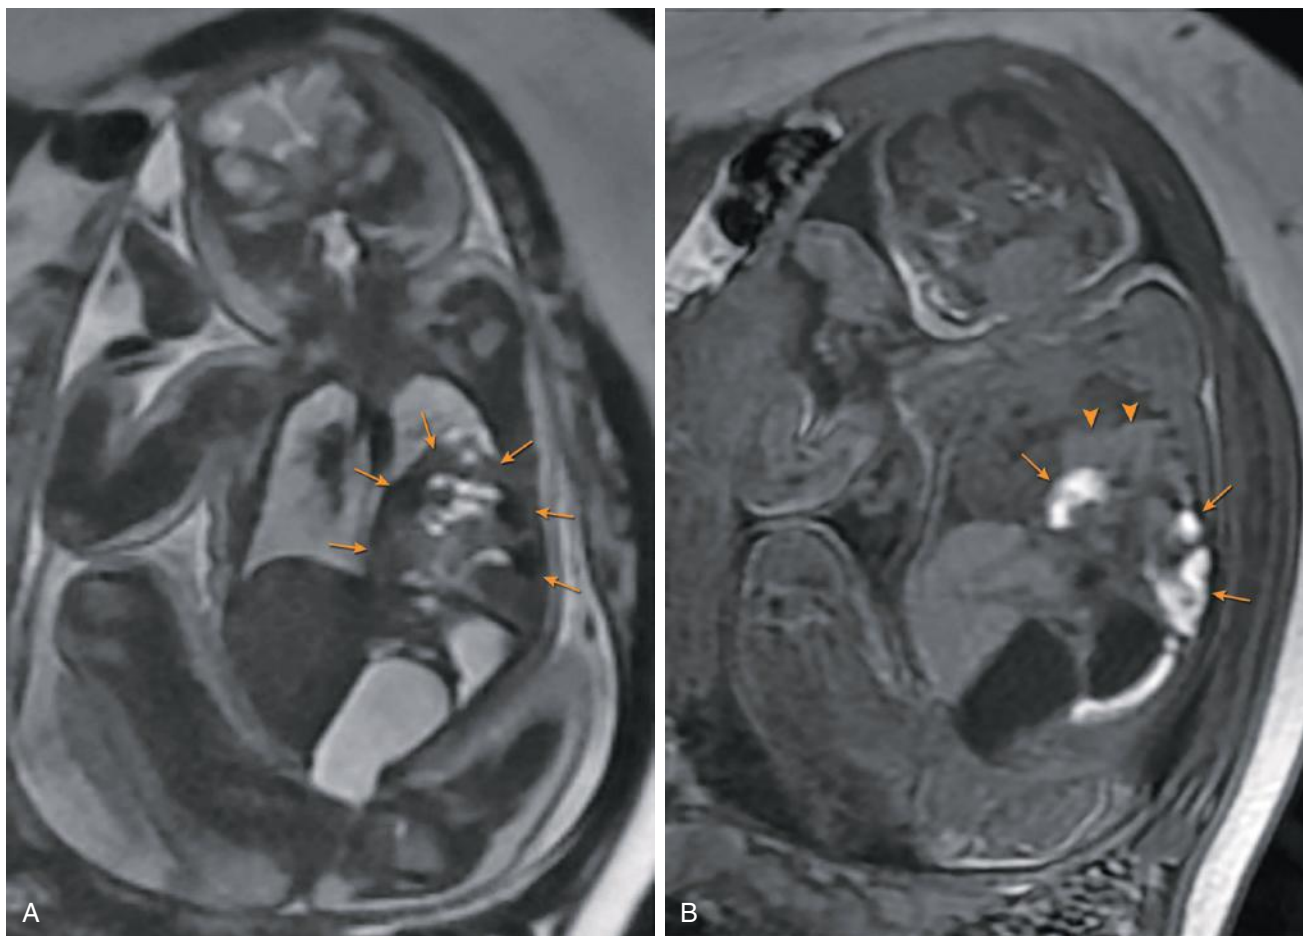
Congenital diaphragmatic hernia (CDH) at 35.5 weeks' gestation. Coronal T2-weighted imaging (A) and T1-weighted imaging (B) demonstrate a large left-sided CDH (arrows) containing left lobe of liver and small and large bowel. The fluid-filled stomach is not herniated, located within the abdomen. T1-weighted imaging demonstrates herniated left lobe of liver (arrowheads) and large bowel segments containing high signal meconium (arrows).
